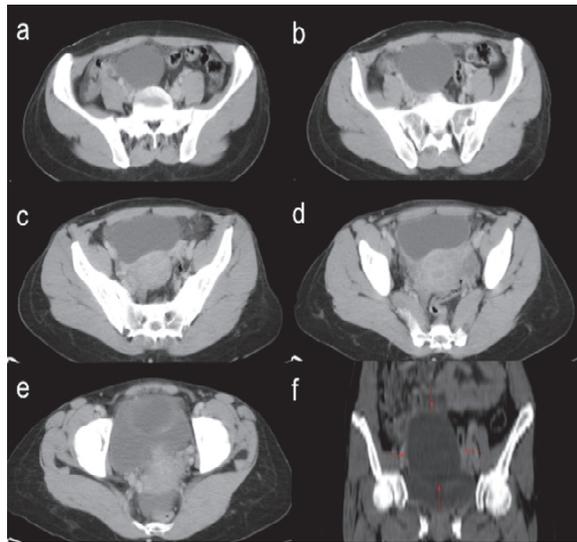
A huge cystic mass, measured 9.5x9x5 cm in width, length and height, detected on axial CT images corresponding pelvic region.
